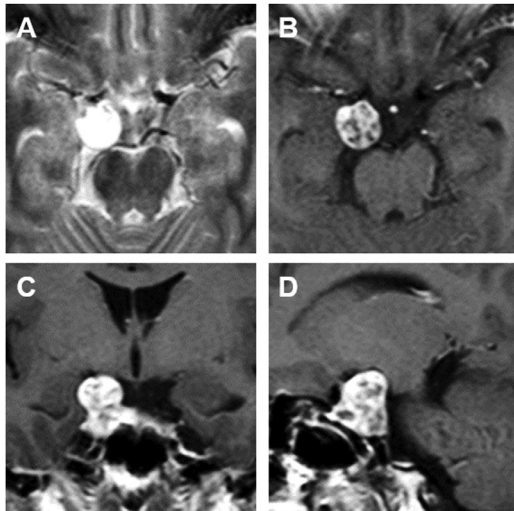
Initial magnetic resonance image of a 15 × 15 × 21 mm lesion in the region of the right posterior clinoid process showing hyperintensity on T2-weighted imaging (A; axial). Gadolinium-enhanced T1-weighted imaging shows heterogeneous enhancement of the lesion (B; axial, C; coronal, D; sagittal)
